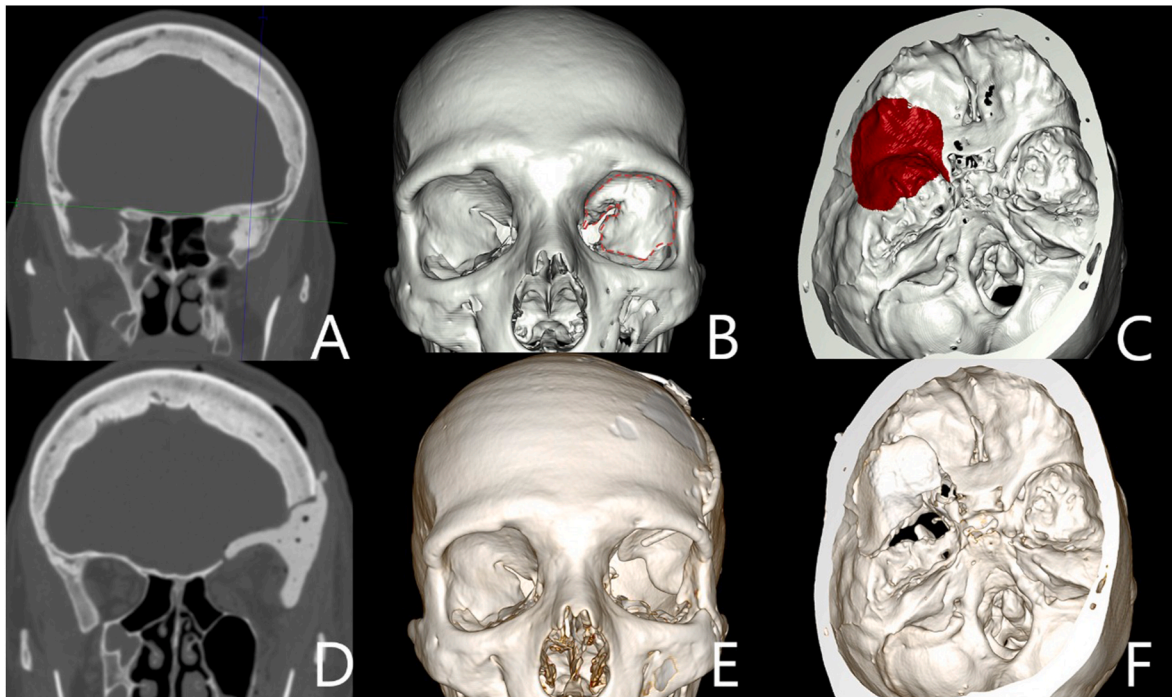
Patient 2. (A–C) Pre-op CT scan showing extent of hyperostosis. (D–F) Post-op CT scan showing position of the implant.
